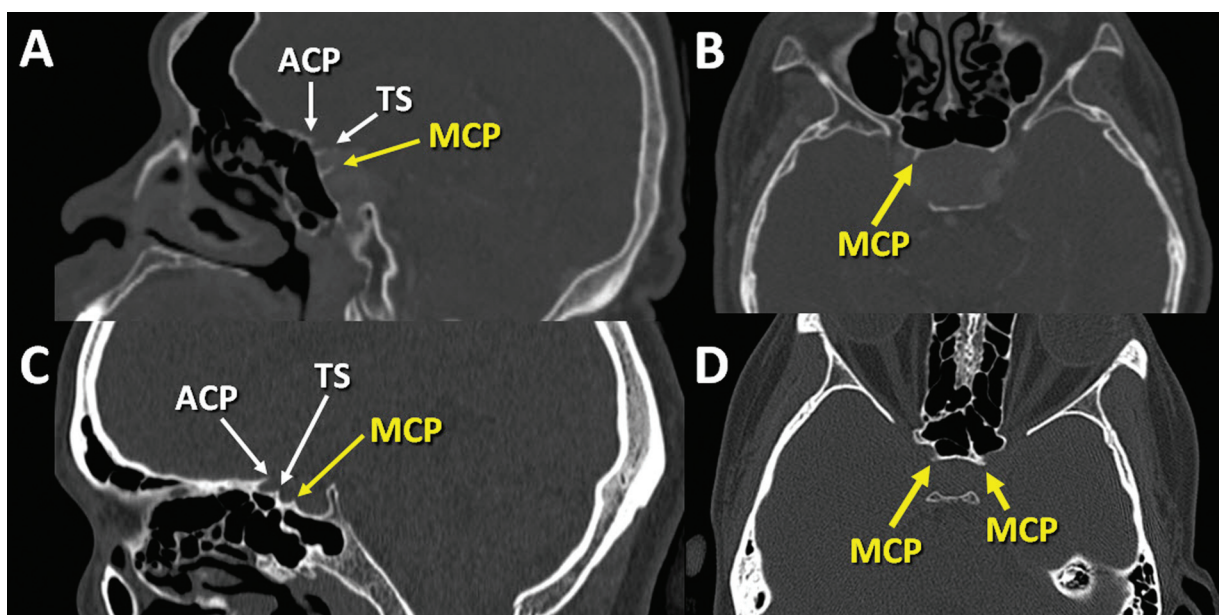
Bone window of cranial computed tomography showing the incomplete type of MCP in a patient with a pituitary adenoma in sagittal (A) and axial planes (B), and in a patient without sellar lesion in sagittal (C) and axial planes (D). ACP, anterior clinoid process; MCP, middle clinoid process; TS, tuberculum sellae.
